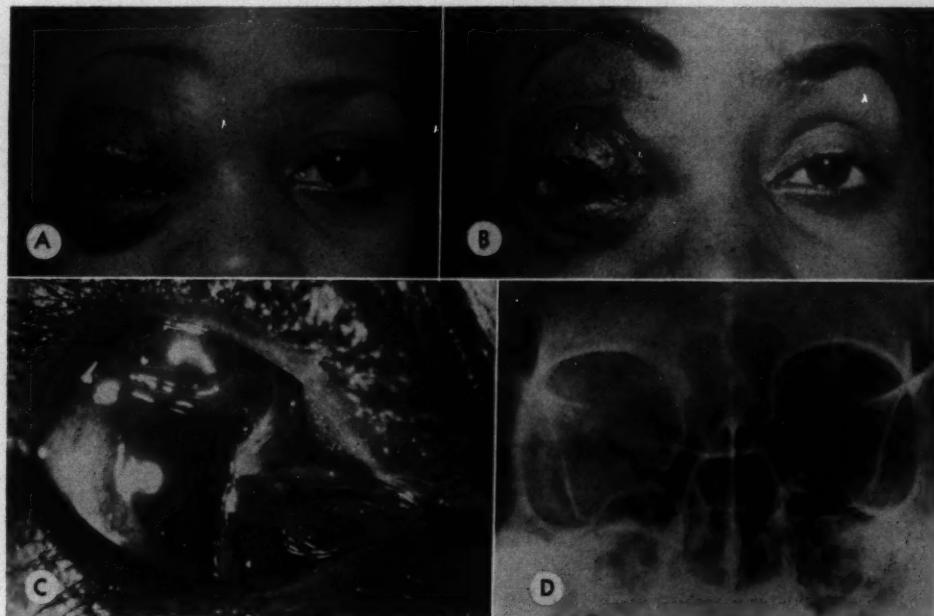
(Jones). *Case 34*. (A) Lymphangioma of the face, lids and orbit 10 years after onset but before treatment. (B) Appearance after surgery and irradiation. (C) Close-up view of the conjunctiva. (D) X-ray film, showing enlarged orbit.
